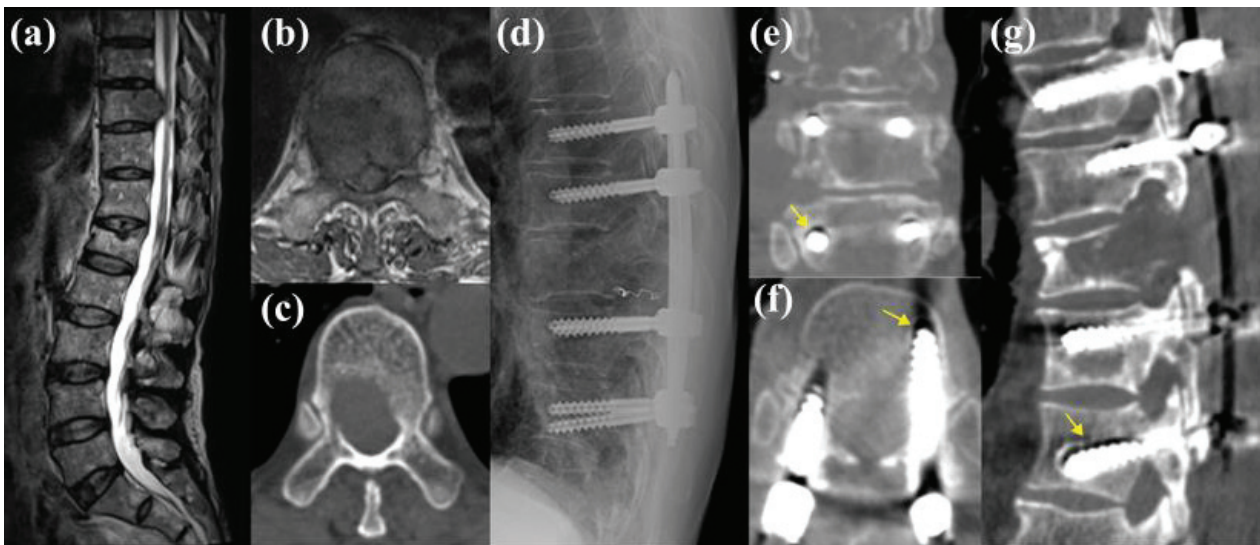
Representative case of a 70-year-old male patient with liver hepatocellular carcinoma metastasis to the T10 vertebra. (a–c) Preoperative magnetic resonance imaging and computed tomography (CT) imaging revealed the metastatic lesion, with a preoperative lowest instrumented vertebra Hounsfield unit value of 94.15, which is below the cutoff value associated with an increased risk of implant failure. (d) The patient underwent decompression with a partial corpectomy and posterior pedicle screw fixation from the T8 to T12. Postoperative plain radiographs initially showed an adequate hardware placement. (e–g) However, 14 months postoperatively, the patient experienced aggravated back pain, and subsequent CT imaging revealed loosening of the T12 pedicle screws (yellow arrows).
